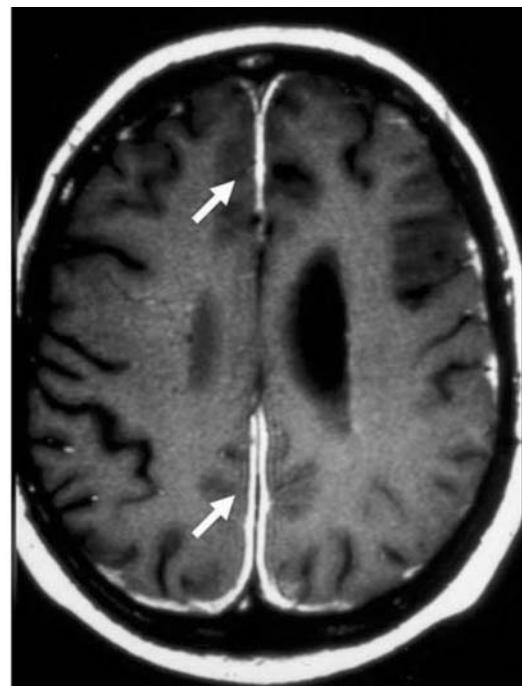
Post-gadolinium T1-weighted MR sequences. Patients with Wegener's granulomatosis. (A) In the parasagittal plane, note the diffuse tentorial thickening attributed to pachymeningitis. (B) In the horizontal plane, note the meningeal thickening and enhancement.
